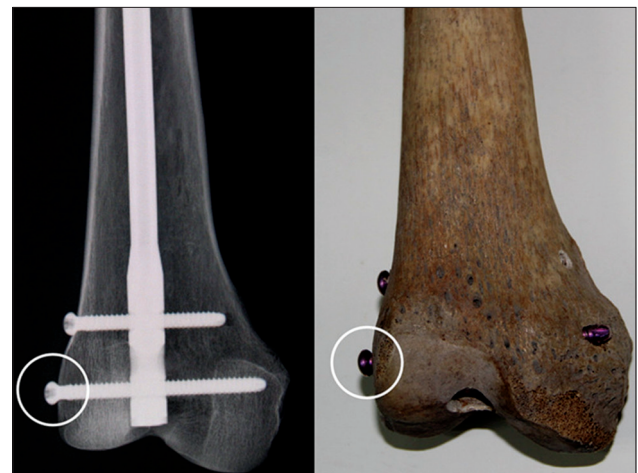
The medial condyle tangential view was obtained by adjusting the direction of X-ray beam external rotation  $\beta$  angle from sagittal plane to the point that X-ray beam was parallel to the medial surface of the distal femur.
